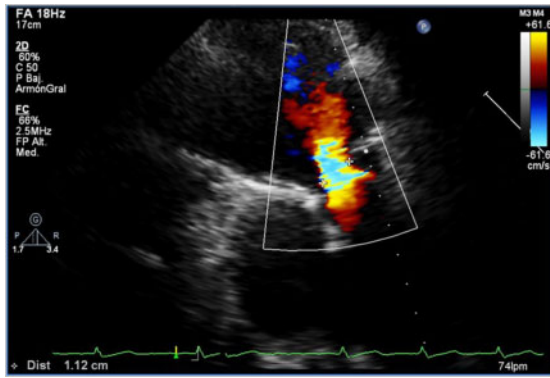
Transthoracic echocardiogram severe pulmonary regurgitation.
